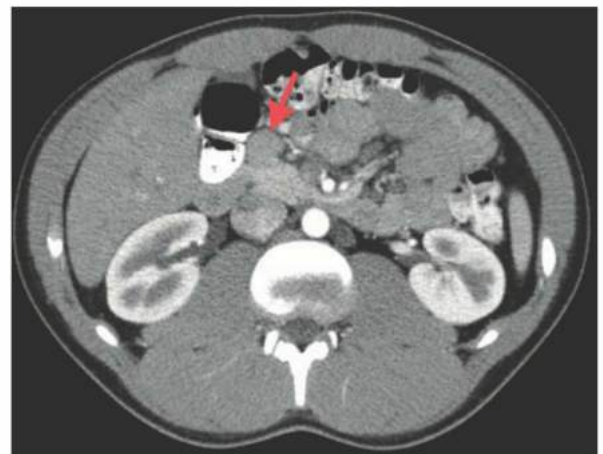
■ CT scan of abdomen showing an insulinoma in the head of the pancreas. It is well circumscribed, consistent with a benign PNET. It is presented as it is unusual; it does not enhance on the arterial phase of imaging. Arrow points to an exophytic insulinoma at the head of the pancreas.
